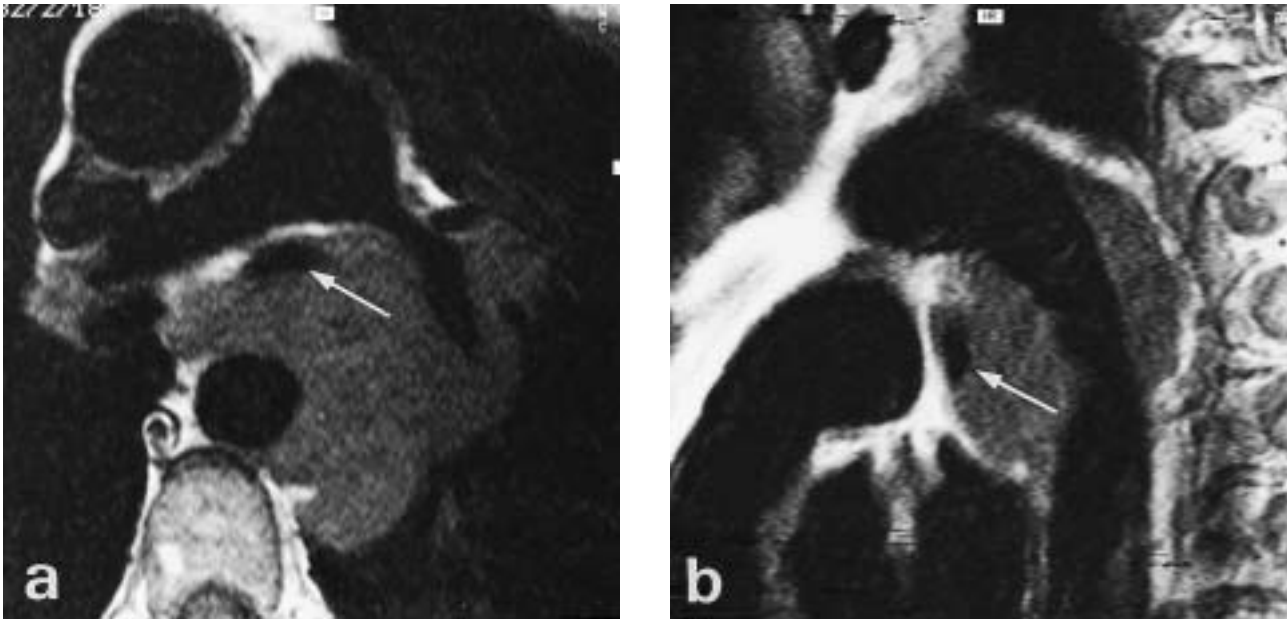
Tumorous aortic invasion. a) Transverse and b) sagittal T1-weighted magnetic resonance images demonstrate broad tumour invasion of the aortic wall by adjacent lung cancer. The perivascular fat layer has disappeared more than 180° of the circumference and more than 2 cm contiguously in the course of the aorta. In addition, mediastinal tumour invasion causes obstruction of the left pulmonary artery, as well as of the anteriorly displaced left main bronchus (arrows).
